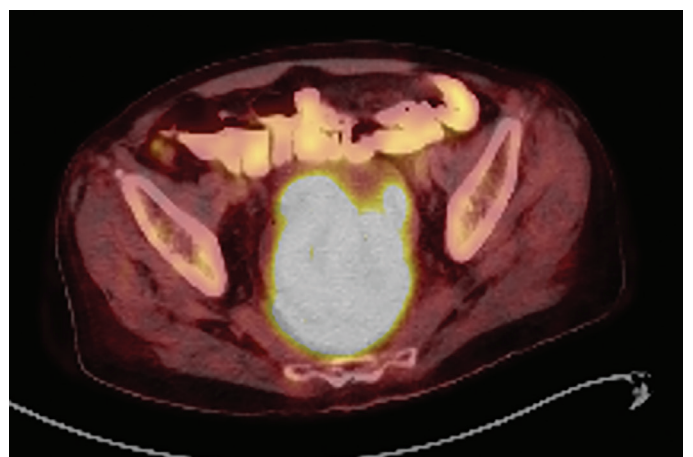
Positron emission tomography-computed tomography view of the hypermetabolic mass in the rectosigmoid
